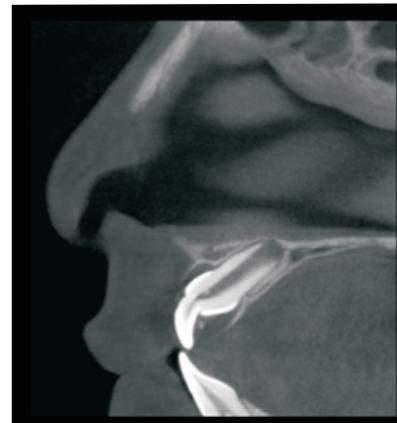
CBCT showing loss of enamel at cervical third of 11
